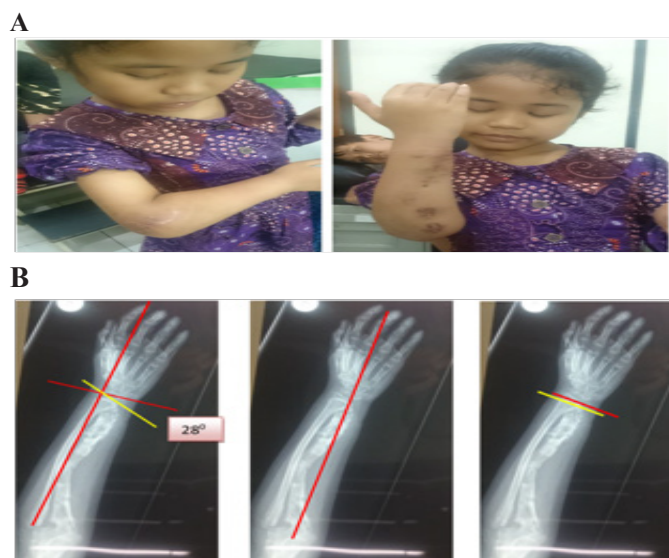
Clinical and radiographic photo of the right forearm in patient 1 A.full range of pronation and flexion elbow at a week after the operation. B. Radiographs after the operation with all of the parameter was normal limit
